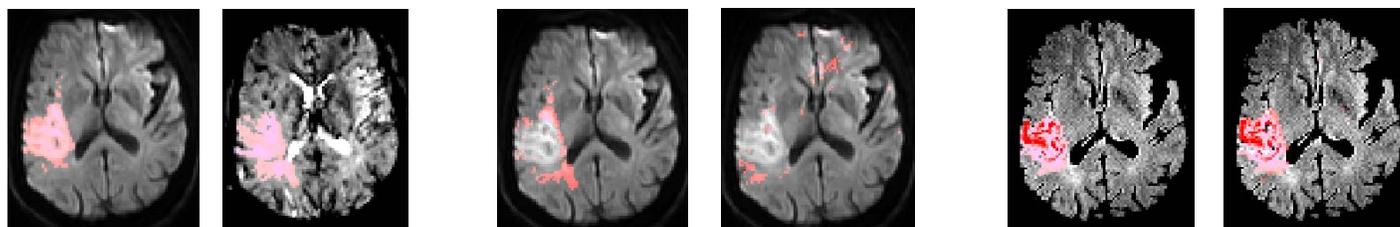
Acute lesion Acute averDWI, expert Fig. 1b: Acute lesion perfusion, expert Fig. 1c: Reversible lesion, averDWI, subtraction Fig. 1d: WMrev + GMrev, algorithm 3, averDWI Fig. 1e: Chronic lesion, 3d-FLAIR, expert Fig. 1f: WMchronic, algorithm 3, averDWI
